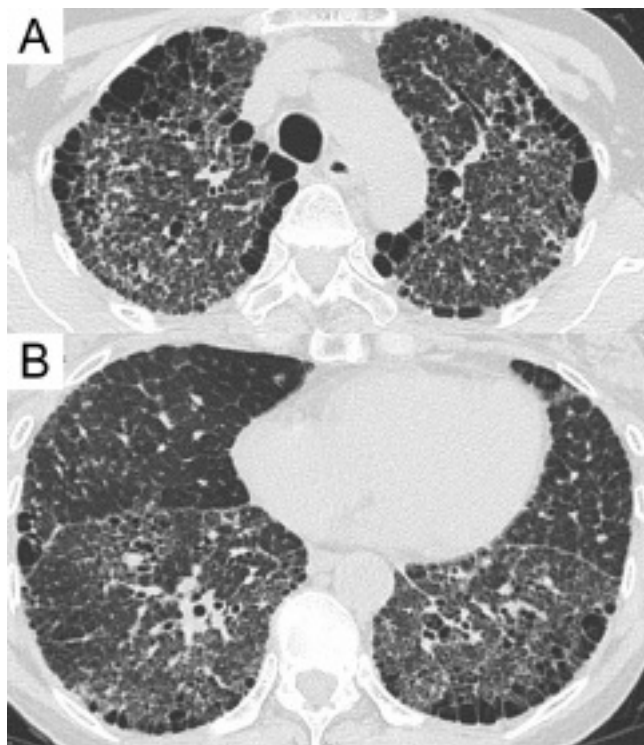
A 67-year-old woman with primary Sjögren's syndrome with anti-SSB/La, accompanied by interstitial pneumonia. Thin-section CT scans at the level of aortic arch (A) and 2 cm above the lung dome (B) show multiple thin-walled cysts in paraseptal distribution, bronchiectasis, bronchiolectasis, ill-defined centrilobular nodules, interlobular septal thickening, intralobular reticular opacities, ground-glass opacities, thickening of bronchovascular bundles, and traction bronchiectasis. Note that aligned multiple thin-walled cysts in paraseptal distribution are predominantly observed in the upper lung zones. In contrast, ground-glass opacities are predominantly observed in the basal lung zones.
